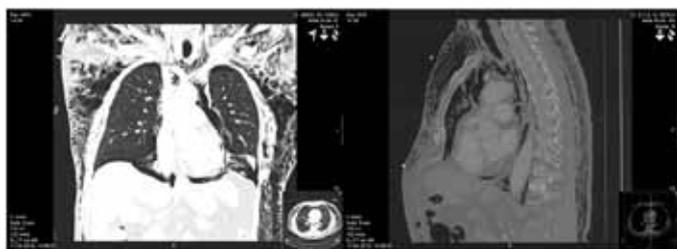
Chest computed tomography scan with intravenous contrast. (A) Marked bilateral apical pneumothorax and basal pneumothorax on the left side, in addition to pneumomediastinum spreading along arcus aortae, (B) Subcutaneous emphysema involving dorsal muscles.
